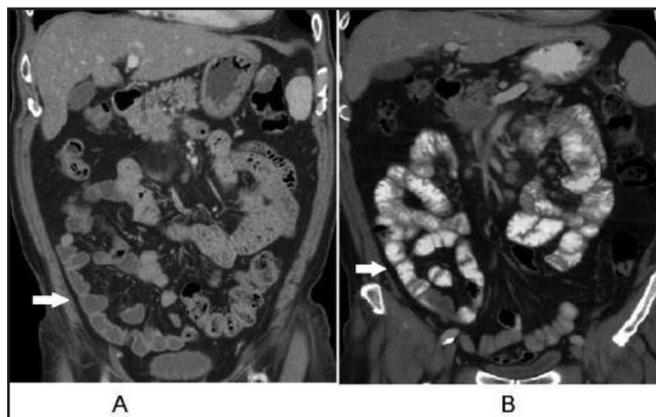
Selected coronal CT images of a 67-year-old male patient with water (A) and gastrografin (B) as OC show comparable bowel wall delineation in the ileum (arrows) with either oral contrast agent.
